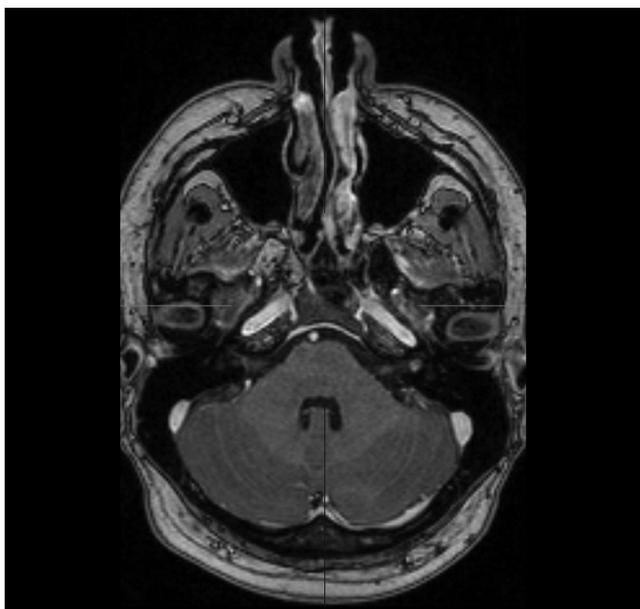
MRI, T1-weighted sequence, transverse plane. A 5.5x3.5 mm, contrast-enhancing lesion in the lateral part of the IAC is seen (corresponding to a meningioma).
